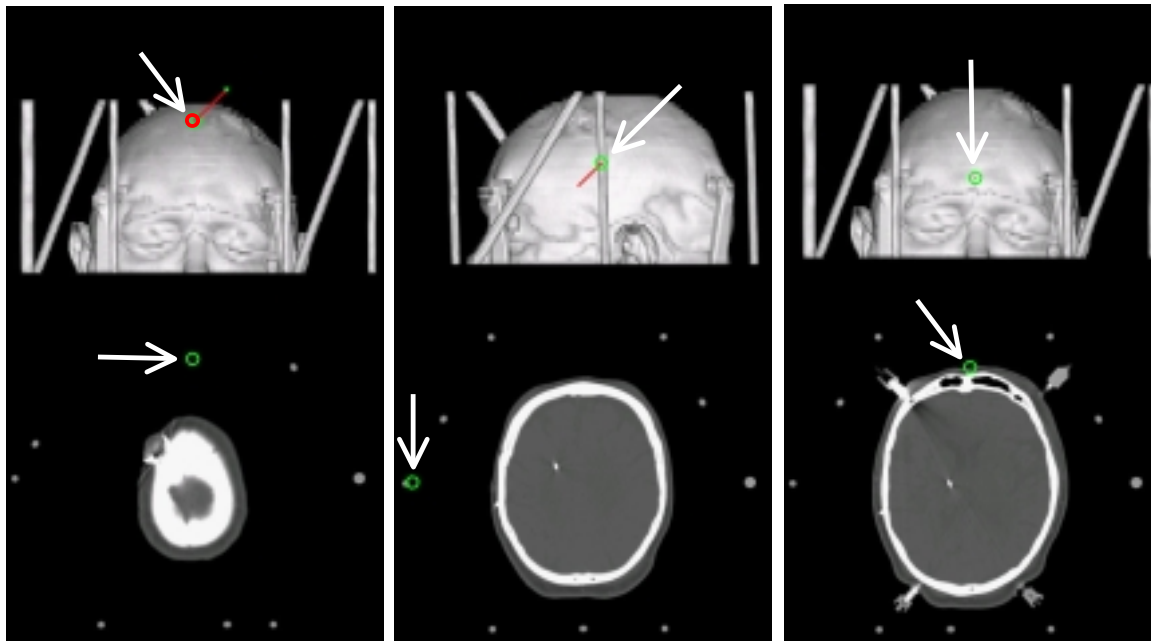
Orion screenshots for three different positions of the probe. The top row shows views from the rendered image set while the bottom row shows the corresponding position on the original CT volume. The three probe positions show when the probe is outside the object depicted on the rendering (left panel), inside the object (middle panel), and touching the object (right panel). The arrows in each image show the cursor representing probe position.
